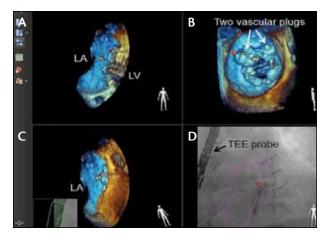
An example of using the EchoNavigator during paravalvular leak closure of a mitral bileaflet mechanical valve. Panels A and B show the 3D TEE volumetric data presented in two views, thus providing the interventionist with a comprehensive display to facilitate the performance of the intervention. The human figure icon represents the perspective of each displayed ultrasound image. In panel C, a portion of the TEE probe with the green outline indicates correct registration. Also in this panel is the 3D TEE image in the same orientation as the fluoroscopic image. The magenta outline (D) is the calculated 3D ultrasound dataset shown as an overlay on the live fluoroscopic images. Finally, a red dot present in all four panels marks the position of the paraval-vular leak thus facilitating the crossing of the leak and device deployement.
